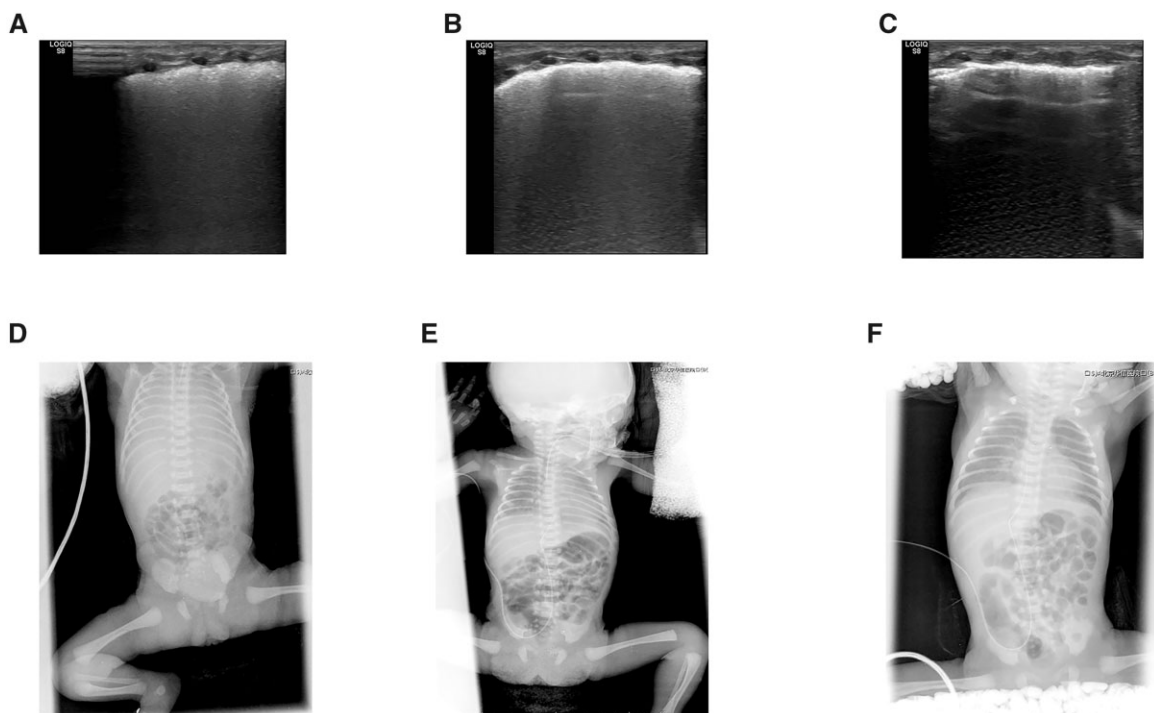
A female NRDS with gestational age 30+ weeks and birth weight of 1540 g. Cesarean section due to placenta previa, admission 1 h after delivery due to dyspnea. The diagnosis of NRDS was confirmed according to clinical manifestation, blood gas analysis and CXR. Lung ultrasound showed (A) and CXR (D) showed white lung in day 1. In day 2, with the improvement of symptoms, the 'A-line' was dimly seen in part of the lung field by ultrasonography (B), and the brightness of the lung field was improved by CXR (E). On the third day, the ultrasonographic findings of the lungs were normal (C). A-line could be seen in all the fields of the lungs. At the same time, CXR showed normal transmittance of the lungs (F).
